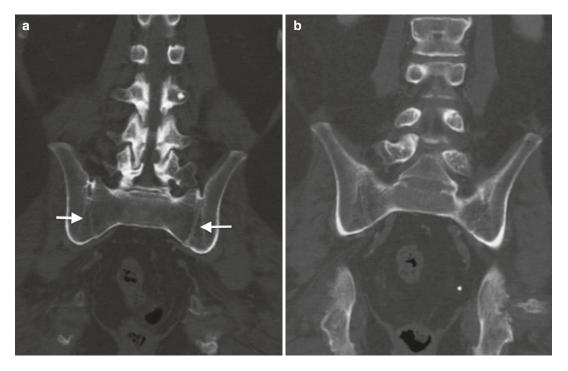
(a, b) Fused SIJs (arrows) in a patient with long-standing paraplegia on coronal reformatted CT
